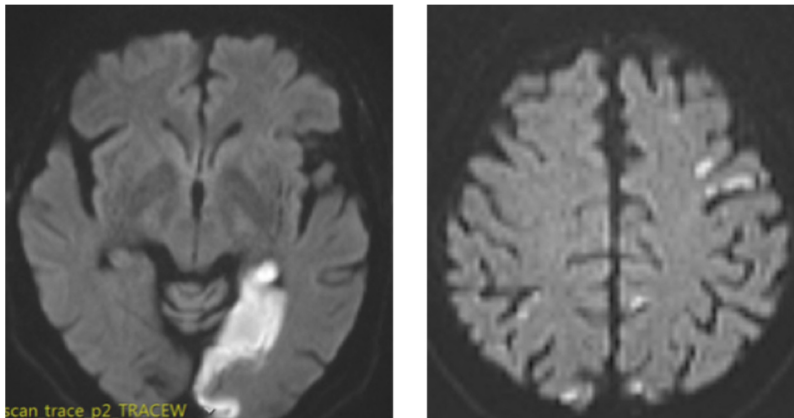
MRI-DWI showing (A) infarction in the left PCA territory, and (B) multiple and bilateral cortical lesions to both the anterior and posterior vascular territories.
